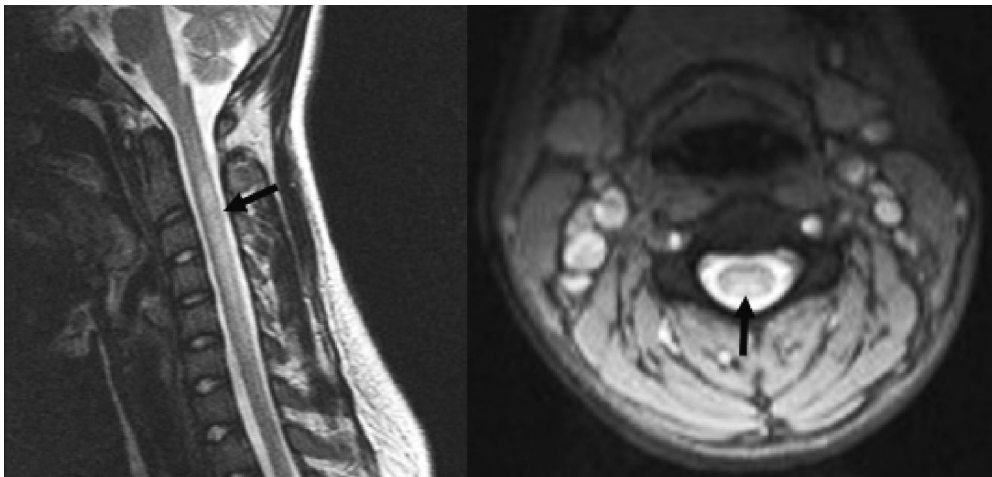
MR findings in a 26-year-old woman with a history of N₂O abuse presented with limb weakness, numbness and spinal myoclonus. (A) T2-weighted sagittal image shows increased signal intensity (black arrow) in the cervical spinal cord between C2 and C7. (B) T2-weighted axial image shows that the abnormal signal involves preferentially the posterior columns at the C4 level.
